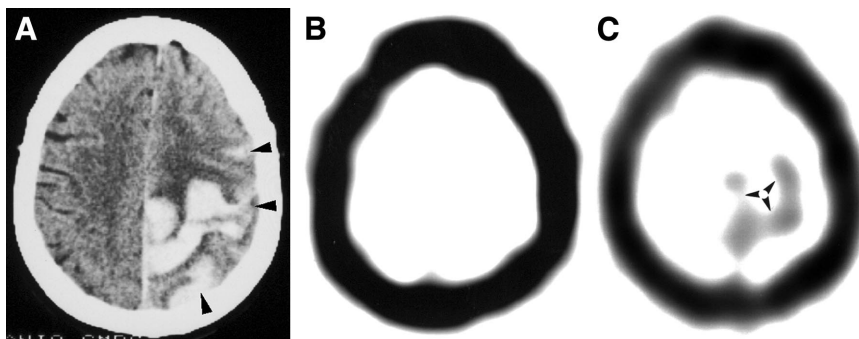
Patient 5, a 76-y-old woman with sudden onset of aphasia, right-sided hemiparesis, and drowsiness. (A) Emergency CT scan shows atypically located hematoma in left frontal region with subarachnoid spreading (arrowheads). Lesion is surrounded by moderate edema. (B) ^{99m}Tc -MIBI SPECT image obtained 2 d after onset of clinical deterioration shows no ^{99m}Tc -MIBI uptake (^{99m}Tc -MIBI index = 1). (C) ^{99m}Tc -MIBI SPECT image obtained 30 d after onset of clinical deterioration shows ringlike ^{99m}Tc -MIBI uptake (arrowheads) (^{99m}Tc -MIBI index = 2).
